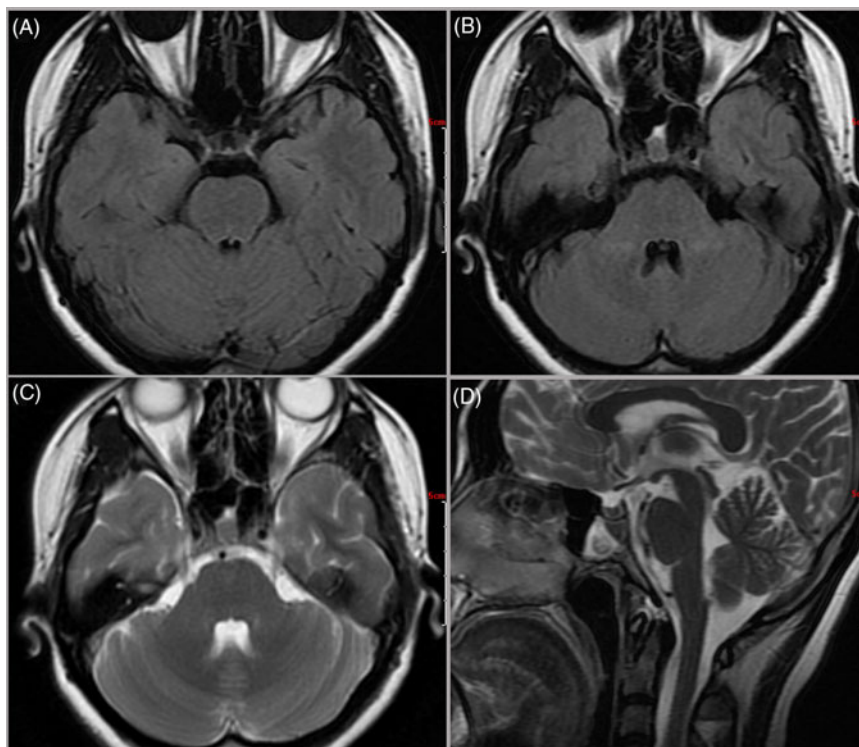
MR images obtained on the 50th day after initiation of corticosteroids showed the lesions completely disappeared (A–D).
